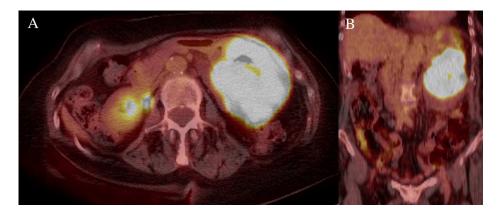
PET-CT skull base to mid-thigh. (A) Axial view demonstrating hypermetabolic gastric mass. (B) Coronal view.
